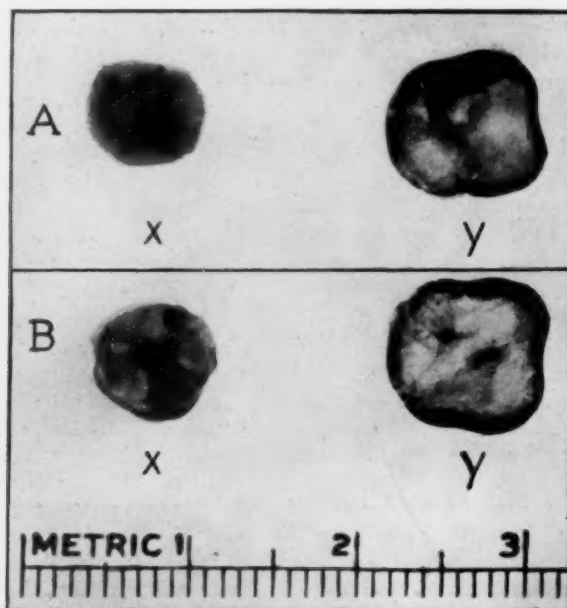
Case 3: A. Roentgenogram of the cystic duct stone (X), and one of the gallbladder stones (Y). B. Photograph of their cut surfaces showing a dark layer about the periphery of Y.
